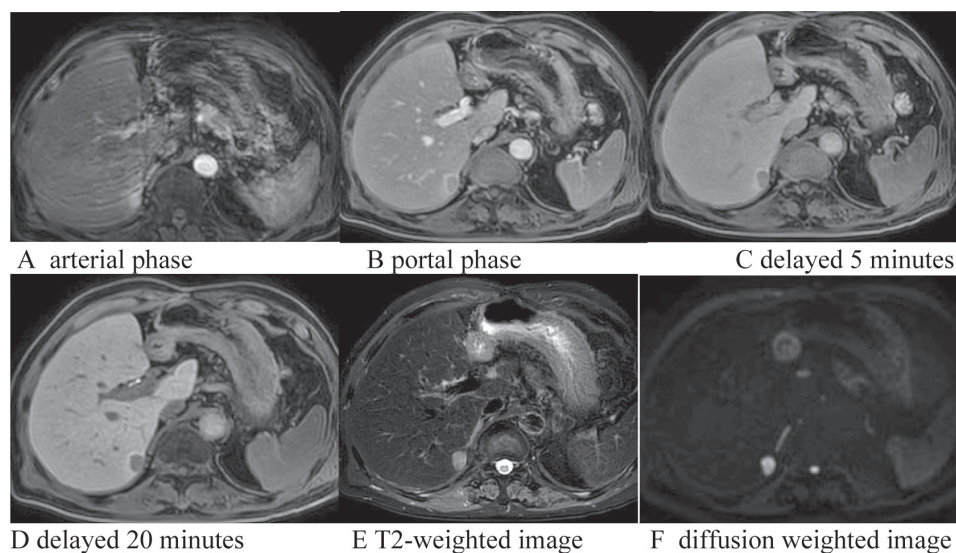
Axial imaged of gadoxedate -enhancement MRI in a 90 - year-old man with chronic hepatitis B and hepatocellular carcinoma (HCC) at segment 6. The liver mass at segment 6 of liver measuring 1.3x1.3 cm in size showed hypersignal intensity on T2 weight (E), arterial phase (A) hyperenhancement, washout on portal phase (B) with visible enhancing capsule. The mass showed restriction (F) on DWI, hyposignal intensity on transitional phase (C) and delayed 20 minutes image (D). This hepatic observation was categorized as LR 5 according to LIRAD version 2018. HCC was confirmed with pathological report. Also noted motion artifact on arterial phase image (A).
